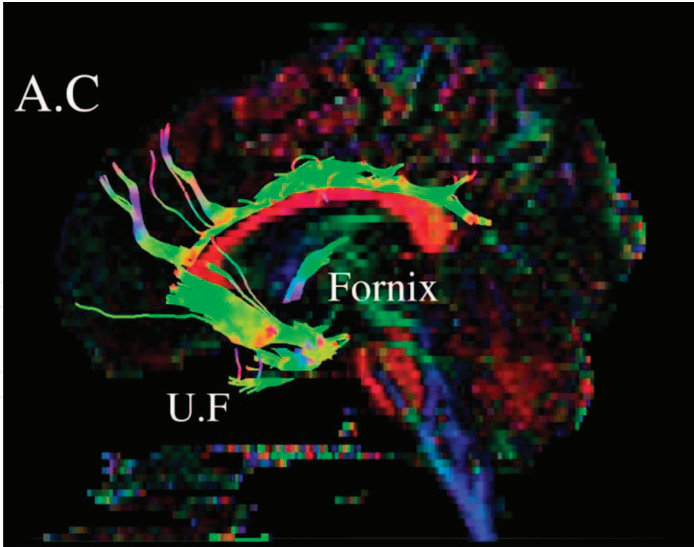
MRI tractography in sagittal view showing anterior cingulate (A.C) fibers, fornix and uncinate fasciculus (U.F) fibers.
